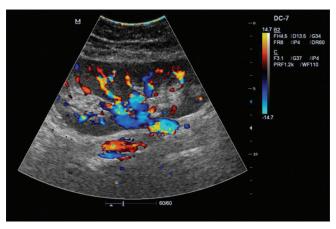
Color Doppler image of the kidney (normal segmental renal arteries and interlobar renal arteries)
